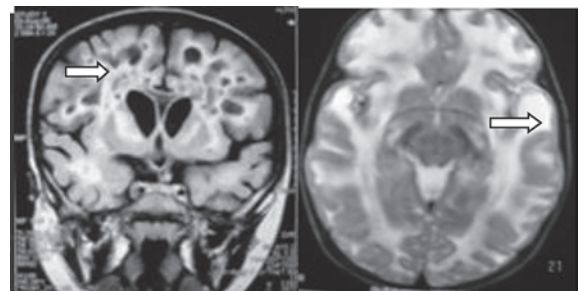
Vanishing White Matter disease Coronal FLAIR shows diffuse white matter involvement with cystic changes
